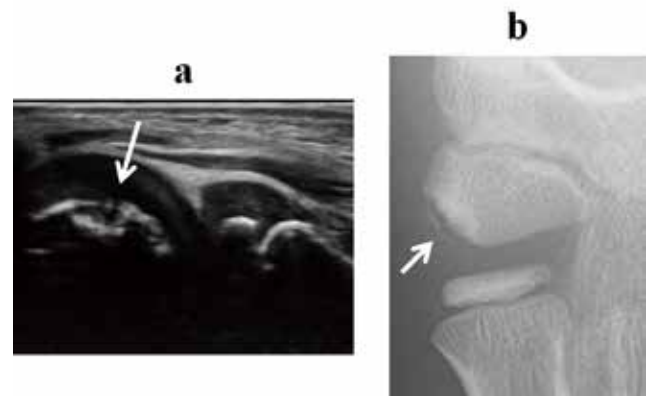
Screening for osteochondritis dissecans of the capitellum using ultrasonography (a) enables early detection and can be confirmed on radiography (b).
